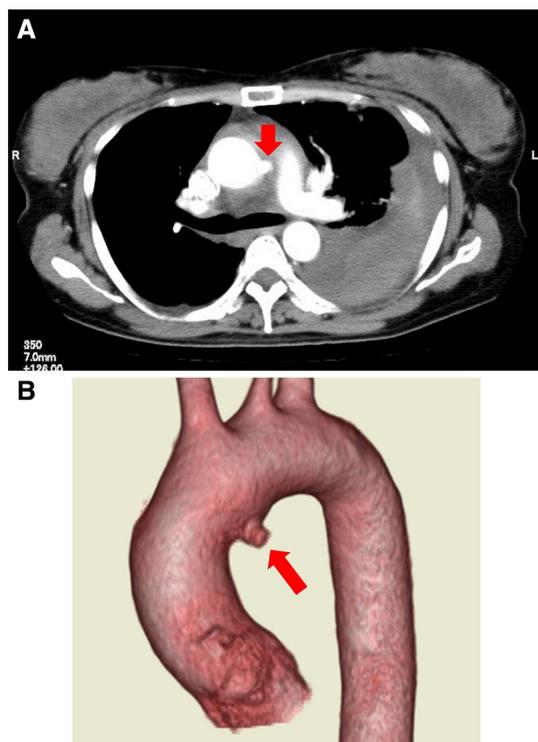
a Preoperative computed tomography (axial view) shows a ruptured ascending aorta (red arrow). There was pleural effusion in the left thoracic cavity. b Three-dimensional computed tomography also shows a ruptured site of the lesser curvature side of the ascending aorta (red arrow)
